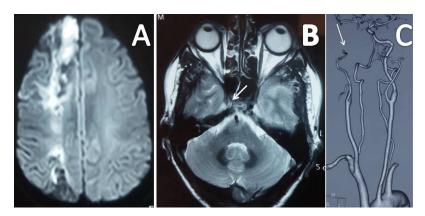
Isointense intraluminal signal. Diffusion weighted-MRI (A) shows acute border zone infarct between right middle cerebral and anterior cerebral artery territory. T2 Weighted-MRI (B) shows isointense intraluminal signal in right RICA (arrow) and CT Angiography of neck vessels (C) shows complete occlusion of cervical right ICA just near to its origin (arrow).
